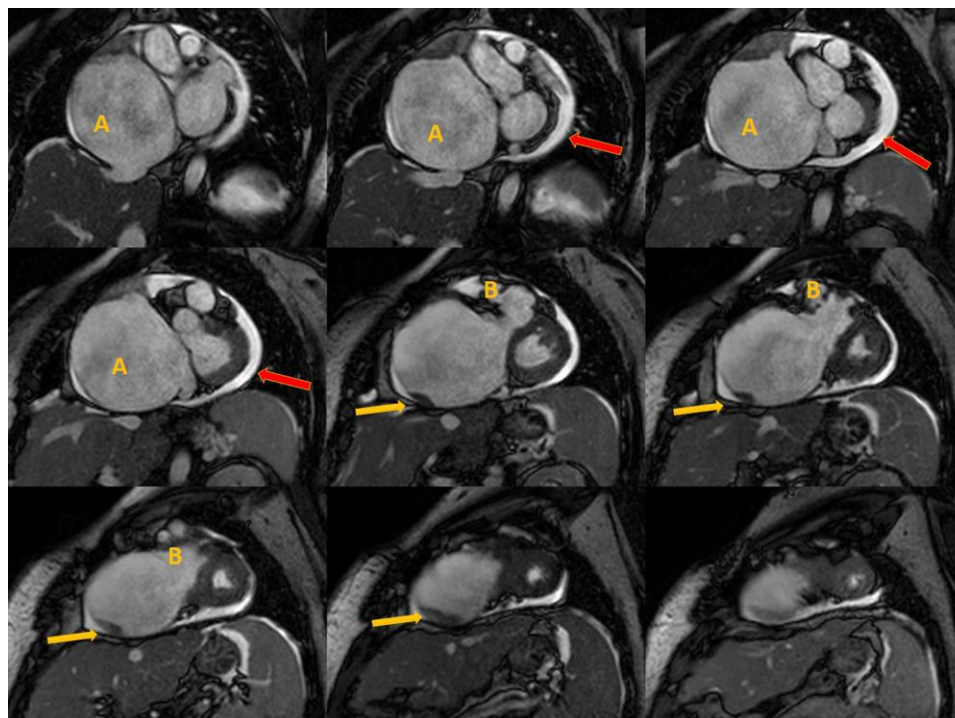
Cardiac magnetic resonance imaging at apical view showed a significant increase in the right atrium (A) with associated thrombus (rightward arrow). Thickening and obliteration of the right ventricle apex (B), and moderate pericardial effusion without signs of restriction (leftward arrow).
